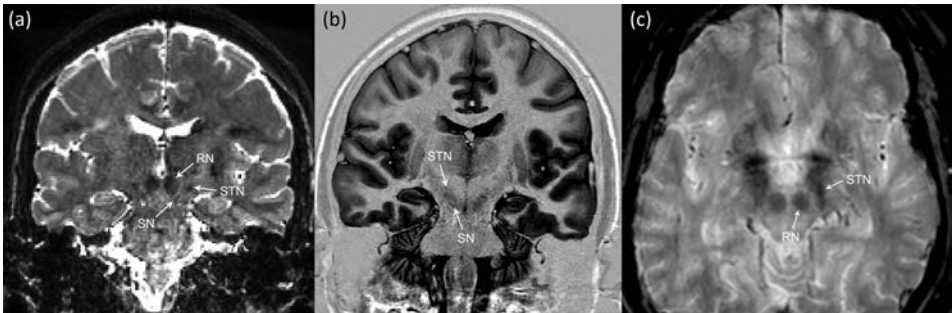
Coronal slices of (a) T_2 -weighted FSE and (b) IR MRI data sets, and an axial slice of an (c) SWI MRI data set, visualizing the STN directly.
